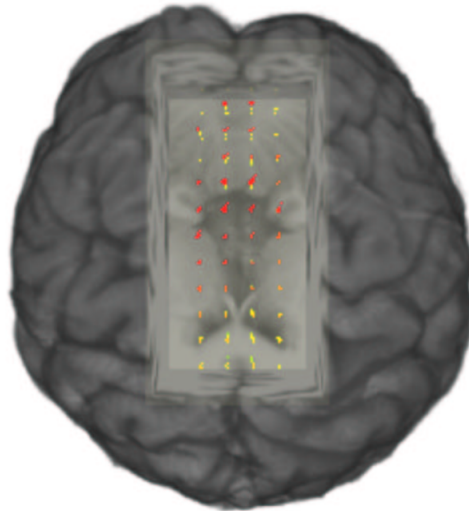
3D texture rendering of individual MRI (T1) slices. Part of the brain is clipped by a parallelepipedic transparent object allowing the user to visualise the cingulate gyrus. The brain is seen from the top.
